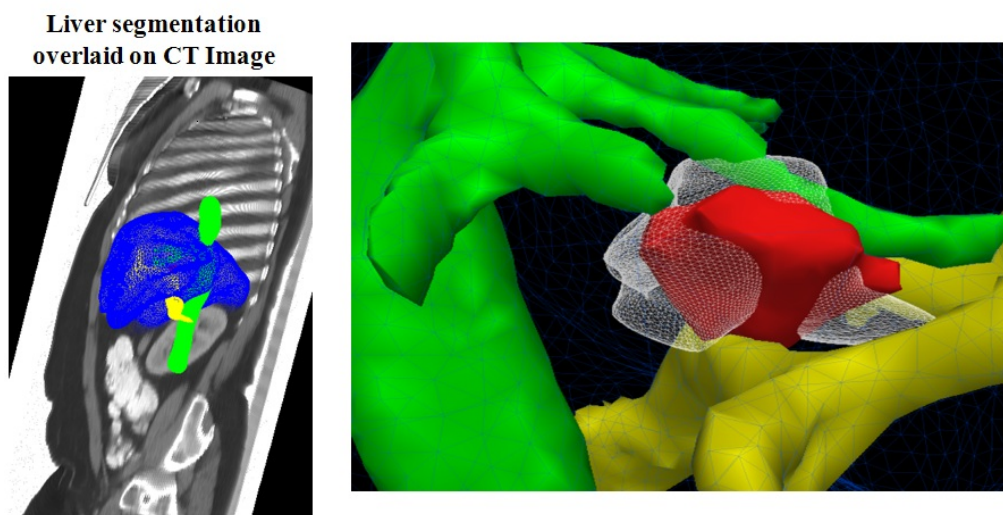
(Left) Anatomical model of the liver estimated from standard clinical CT image. (Right) The predicted necrosis computed with our model compares qualitatively well with the necrosis region observed on a post-operative MRI scan.
